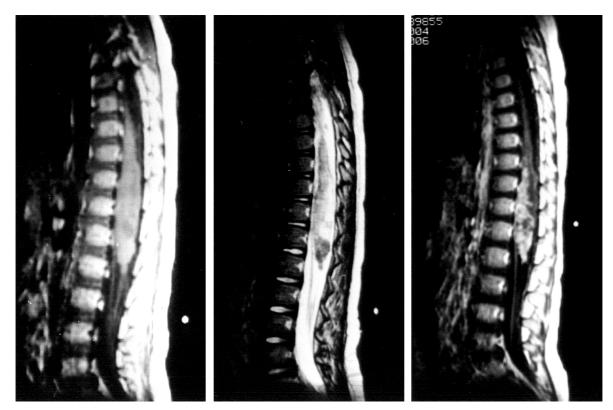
Unenhanced mid- sagittal spin echo T1-weighted MR image of the thoracolumbar spine.
